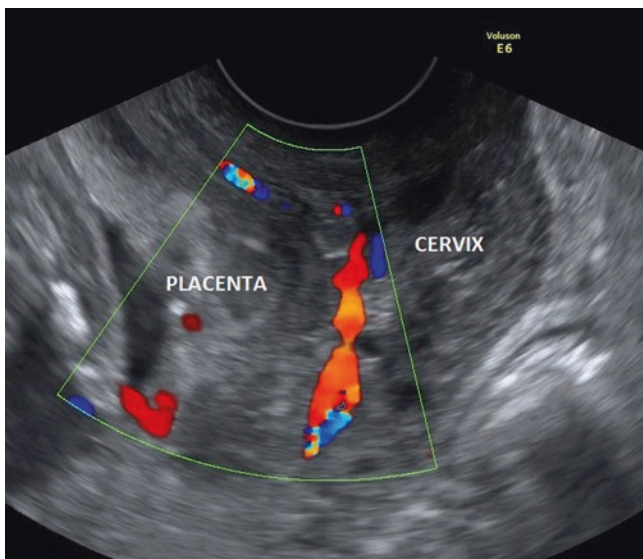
Transvaginal presentation with color Doppler of placenta previa. Sonogram of a 35-year-old patient in 26 weeks of gestation presenting moderate vaginal bleeding
